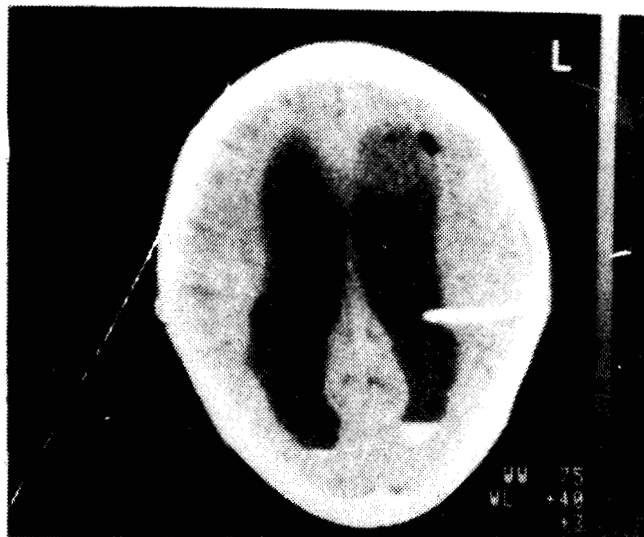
Post shunt CT revealed persistent sever hydrocephalic changes yet with ↓ in the V.S.L. C.S.F. blood fluid level and air loculi are seen within left ventricle (post shunt) (same patient in Fig. 3a).
